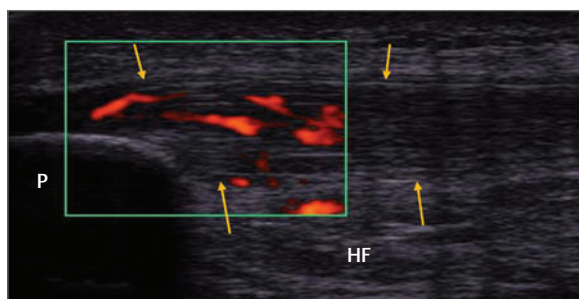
Longitudinal image of the proximal patella tendon. The rectangular box indicates Power Doppler imaging. The image demonstrates some thickening of the proximal patella tendon and with Power Doppler in place, there is a clear neovascularity throughout the tendon. These findings indicate a proximal patellar tendinopathy, commonly termed “jumper’s knee.” HF, Hoffa’s fat pad; P, patella; yellow arrows, patella tendon.
